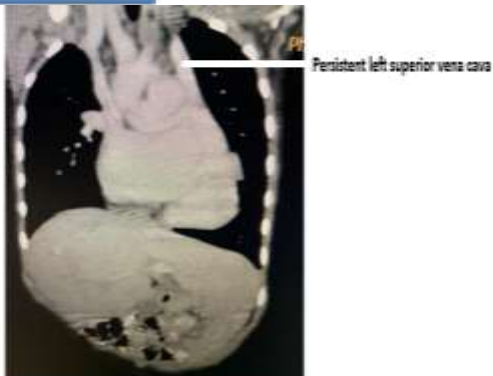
CT thorax showing persistent left superior vena cava.
